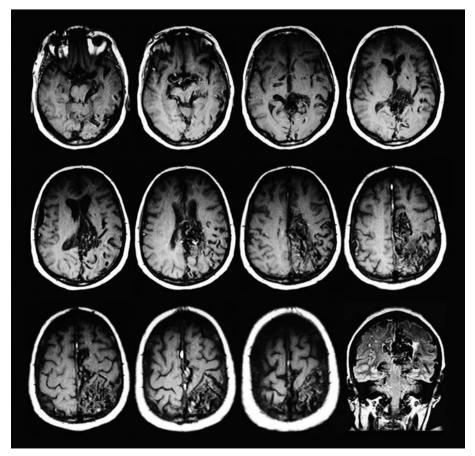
MRI T1-weighted images showing multiple flow voids and engorgement of arteries and veins (axial slices) and Flair (coronal slice).
